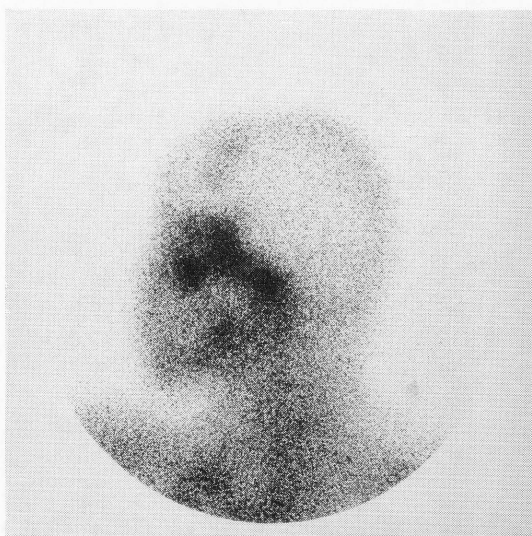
The head (A) and the chest (B) of gallium scintigraphy performed 72 hours after the intravenous administration of 3 mCi of gallium-67 citrate showed a moderate uptake in the lesions.
